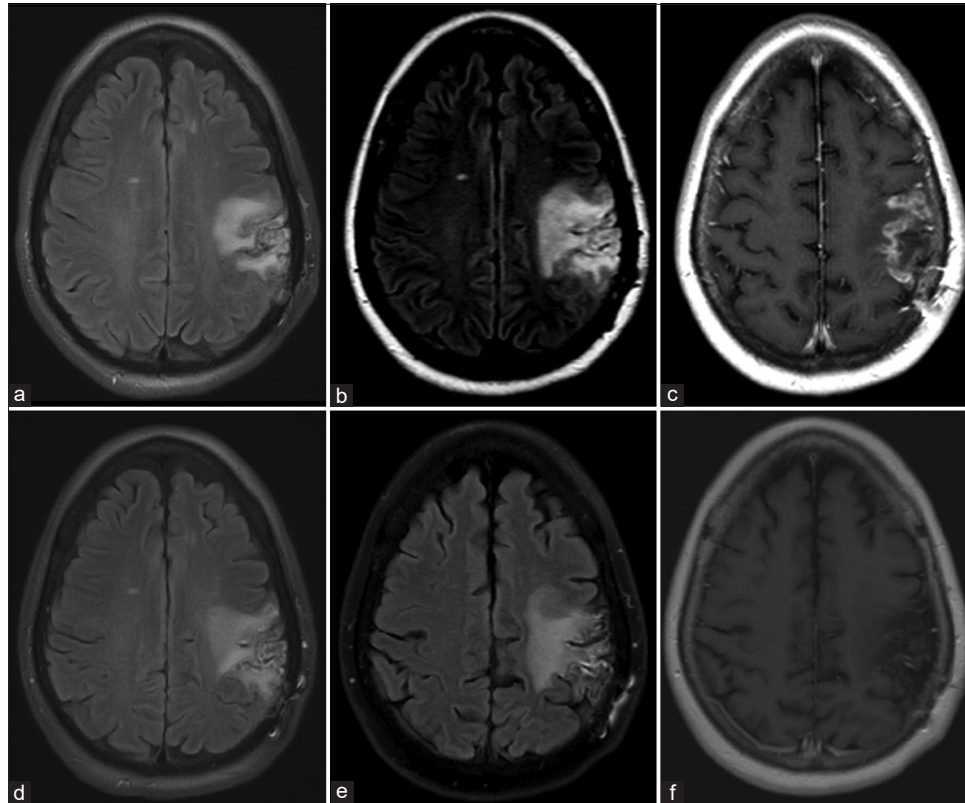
Follow-up neuroradiologic images. One-month postoperative representative axial T2-weighted FLAIR image (a), 2-month postoperative representative axial T2-weighted FLAIR image (b), 2-month postoperative representative axial T1-weighted postgadolinium contrast image (c), 4-month postoperative representative axial T2-weighted FLAIR image (d), 1-year postoperative representative axial T2-weighted FLAIR image with appreciated stable FLAIR signal (e), 1-year postoperative representative axial T1-weighted postgadolinium contrast image with no appreciated contrast-enhanced disease (f).
